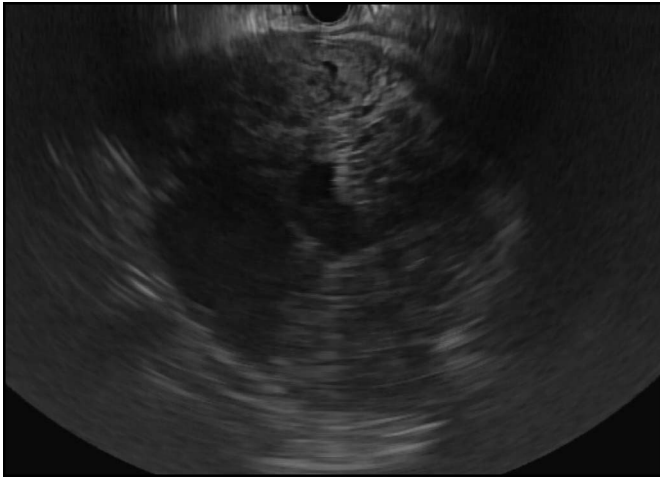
Endoscopic ultrasound demonstrating a 9-cm hypoechoic pancreatic mass.
